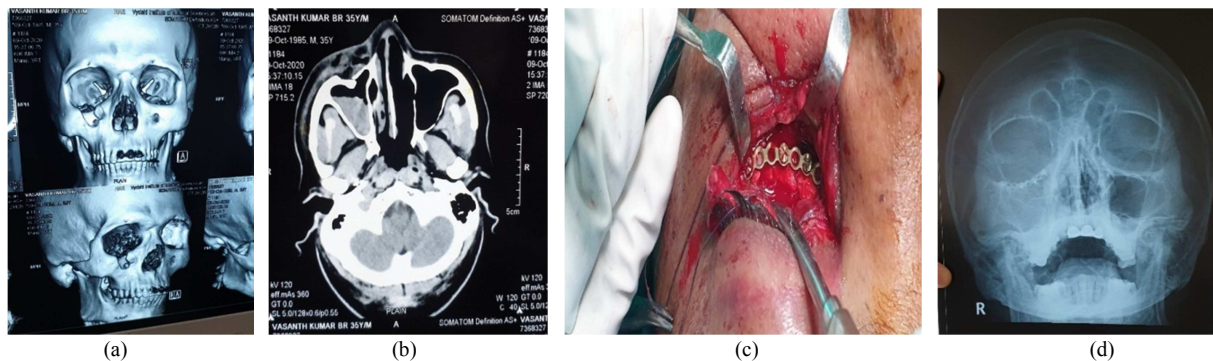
(a) and (b) CT skull and orbit images showing impure orbital floor fracture, (c) intraoperative picture of titanium mesh insertion (d) postoperative radiological image with titanium mesh in situ.
